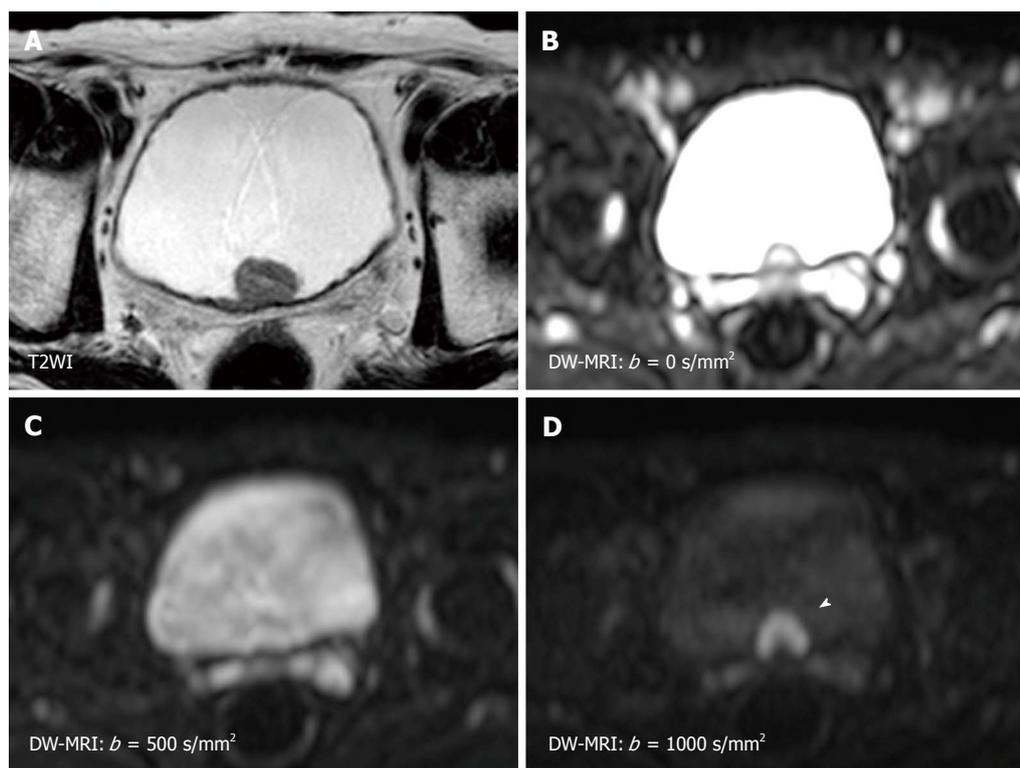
Magnetic resonance images of a 79-year-old man with non-muscle invasive bladder cancer (urothelial cancer, stage pTa, grade 2 > 3). A: T2WI shows a hypointense tumor at the trigone; B: The signal intensity of diffusion-weighted magnetic resonance imaging depends on both water diffusion and the T2 relaxation time; C: Due to the very long T2 relaxation time of urine, the signal of the urine in the bladder remains high on the diffusion-weighted magnetic resonance imaging with a b -value of 500 s/mm². This is known as the “T2 shine-through effect”; D: Using a b -value of 1000 s/mm² decreases the signal of the urine, as well as those of the seminal vesicles, while the bladder cancer (arrow head) shows little signal attenuation with the increased b -value.
